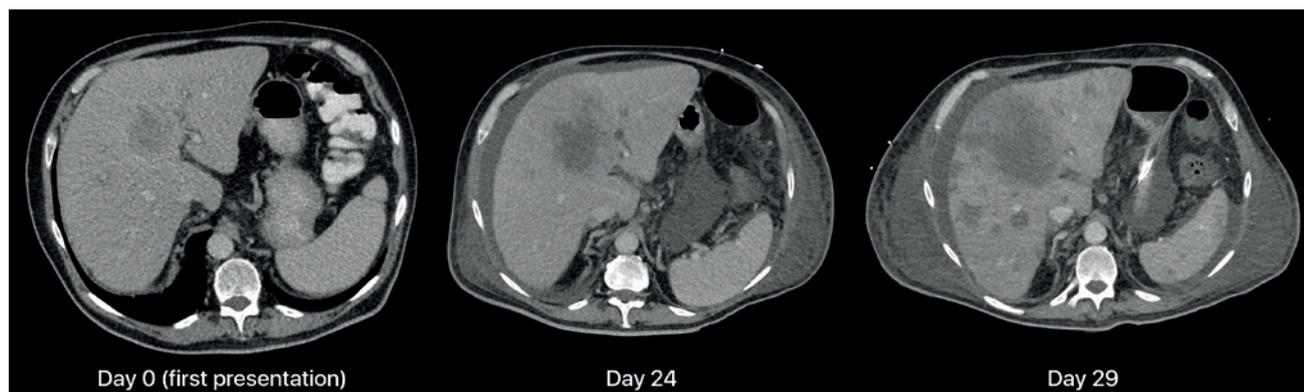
CT imaging at specified times during the course of the disease
